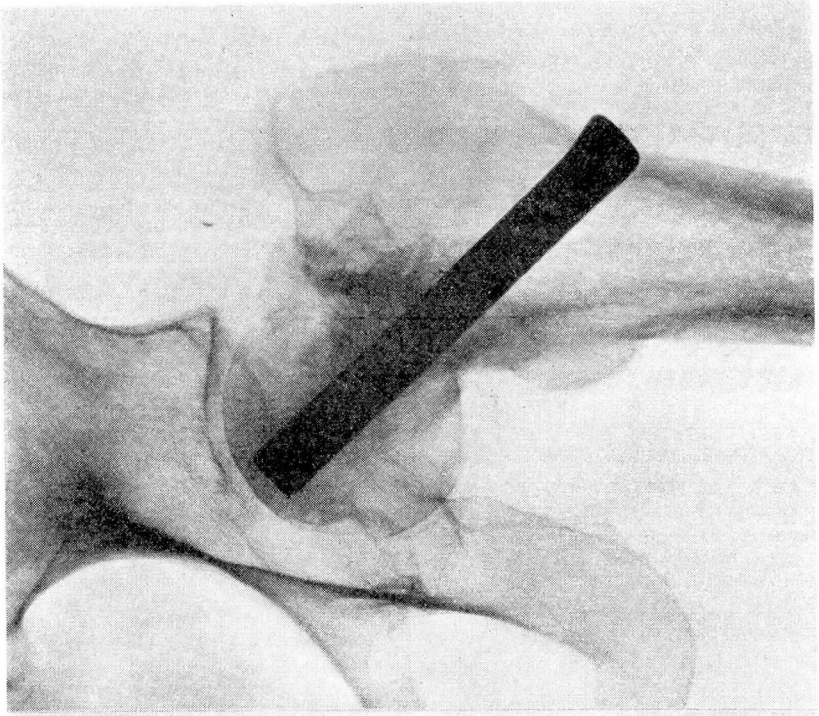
Case 1. Roentgenogram showing result 12 weeks after operation.
